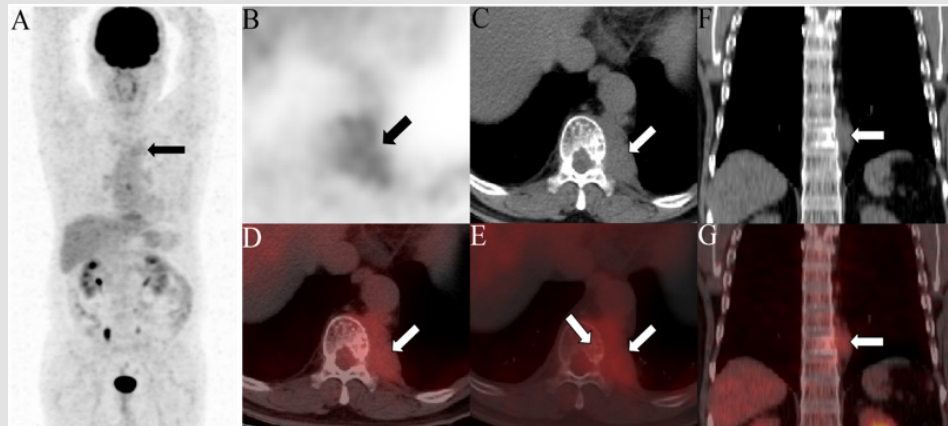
The patient underwent the ^{18}F -FDG PET/CT for tumor staging. The maximum intensity projection (MIP) image (A) demonstrated a minimal radioactivity (arrow) in the left mediastinum. The axial (B: PET, C: CT, D: PET/CT fusion imaging), coronal (F: CT and G: PET/CT fusion imaging) images of the chest displayed a lesion (arrow) with the biggest size of $62 \times 43\text{mm}$ and a SUV_{max} of 3.59 in the left posterior mediastinum.
